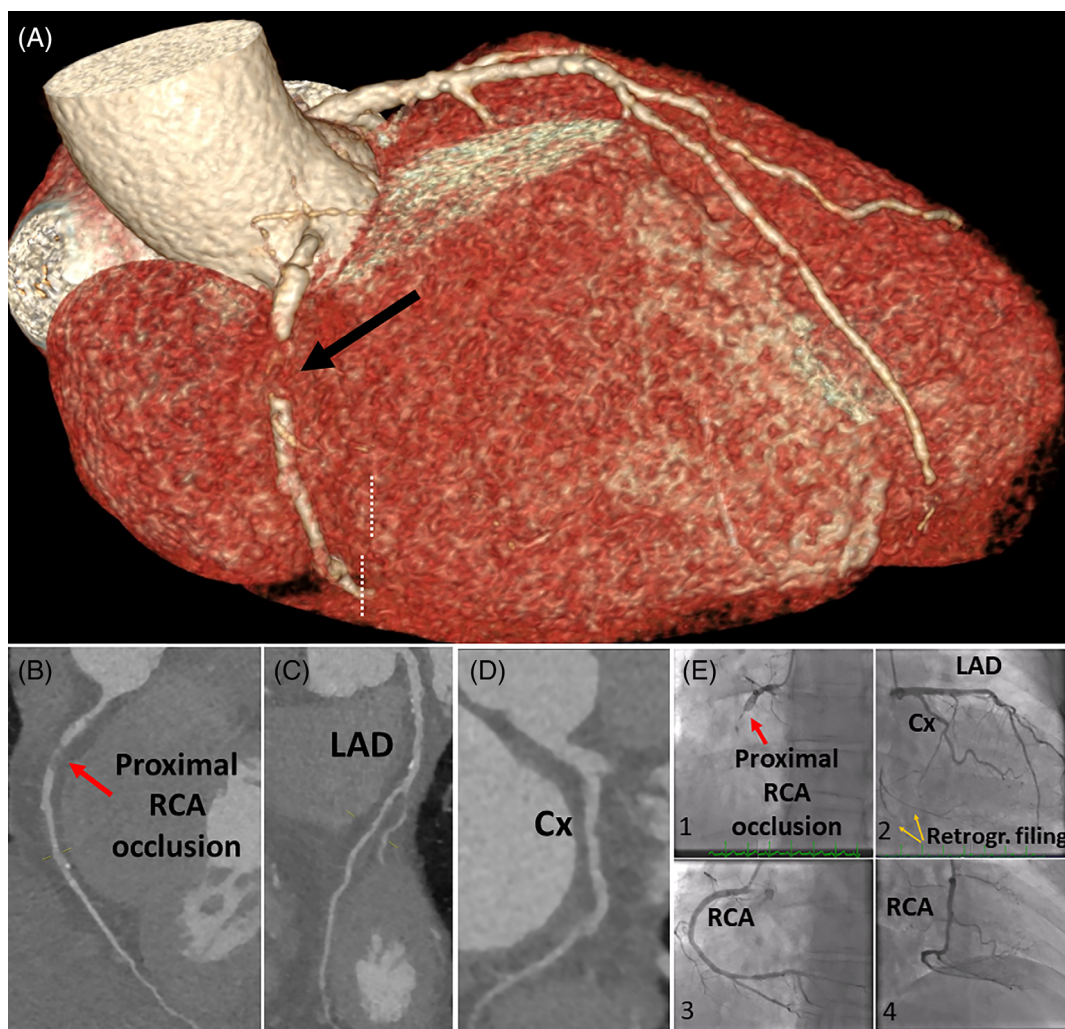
Cardiac computed tomography (CT) (A–D) and conventional angiography (E1–E4) images, showing occluded proximal RCA, treated with percutaneous coronary intervention (PCI) (E3 and E4). Cx, circumflex; LAD, left anterior descending; RCA, right coronary artery
